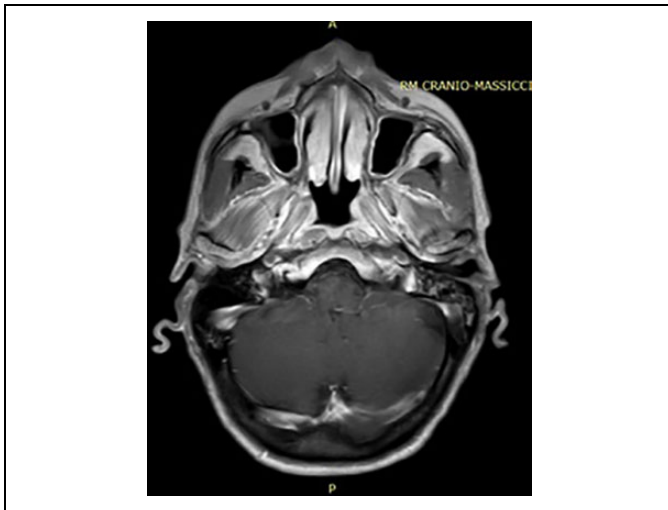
Magnetic resonance imaging (MRI) with contrast after one year by treatment.
